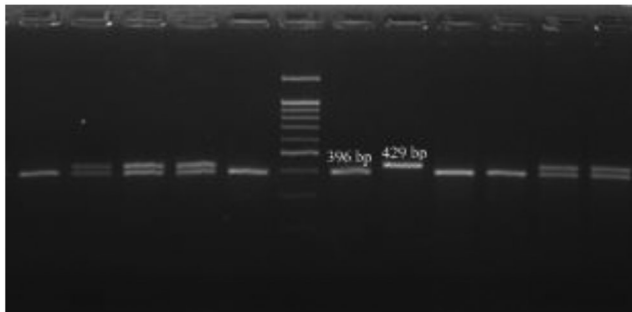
Gel image of PDYN rs1022563 polymorphism. (1st well CC, 2nd well CT, 6th well 100 bp DNA marker, 8th well TT).
